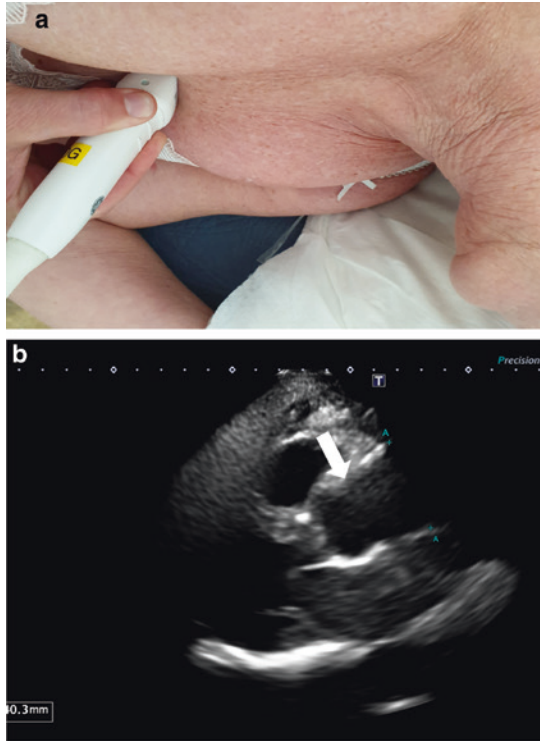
Examination of the ascending aorta and the aortic valve: a recommended transducer position, b ultrasonographic view of the ascending aorta (white arrow)
